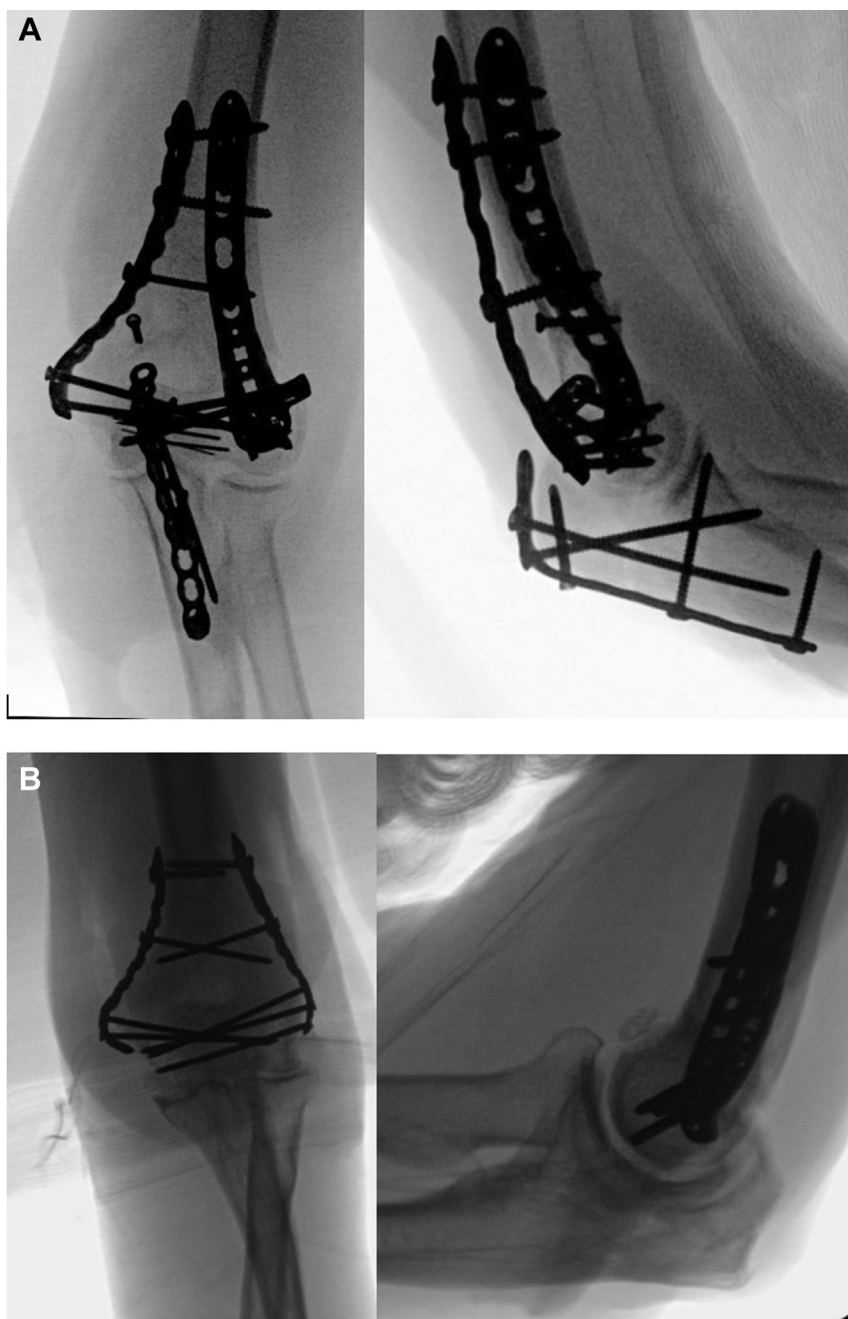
AP and lateral radiographs of the elbow demonstrating (A) an orthogonal plating construct with additional lateral support to allow for transcondylar screw placement into the medial condyle and (B) a parallel plating construct.
